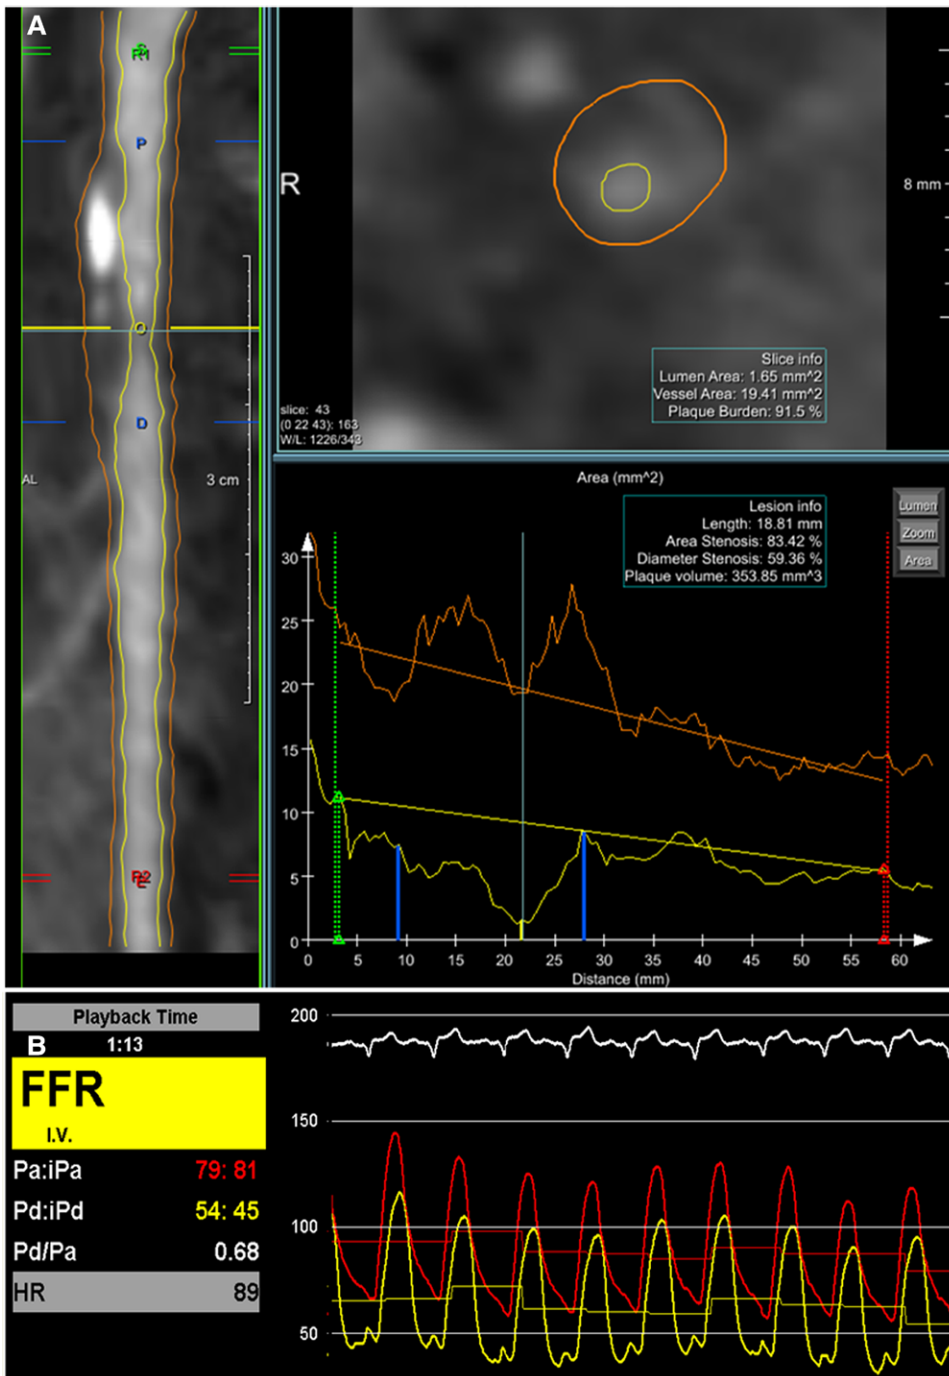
Quantitative computed tomographic coronary angiography (CTCA) and fractional flow reserve (FFR) measurement in a moderate coronary lesion. Example of a patient with a moderate (50%–70% lumen narrowing by visual CTCA) coronary lesion because of a partly calcified plaque in the left descending coronary artery. A, The screenshot of the quantitative CTCA analysis using dedicated software. The lesion was assessed as moderate by visual CTCA. Lumen (yellow) and wall (orange) contours were semiautomatically detected. At the level of the minimal lumen area (yellow line), lumen area, % area stenosis, and plaque burden were measured as 1.6 mm², 83%, and 91%, respectively. The FFR was 0.68 (B).
